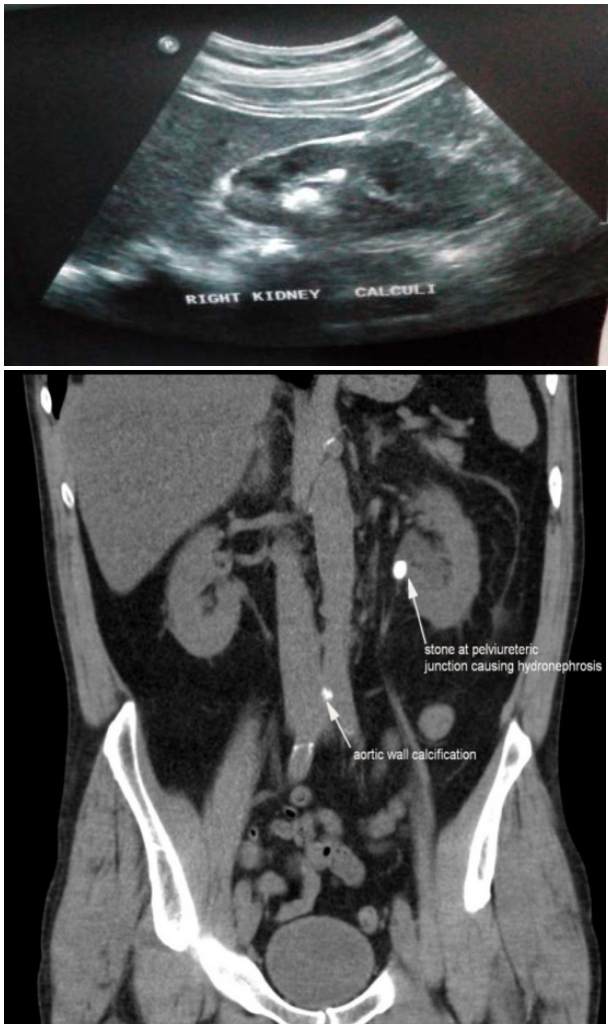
Ultrasound (a) and Coronal reformatted CT image (b) showing hyperechoic calculus in upper calyx of right kidney (a) and hyperdense calculus in left renal pelvis (b).
